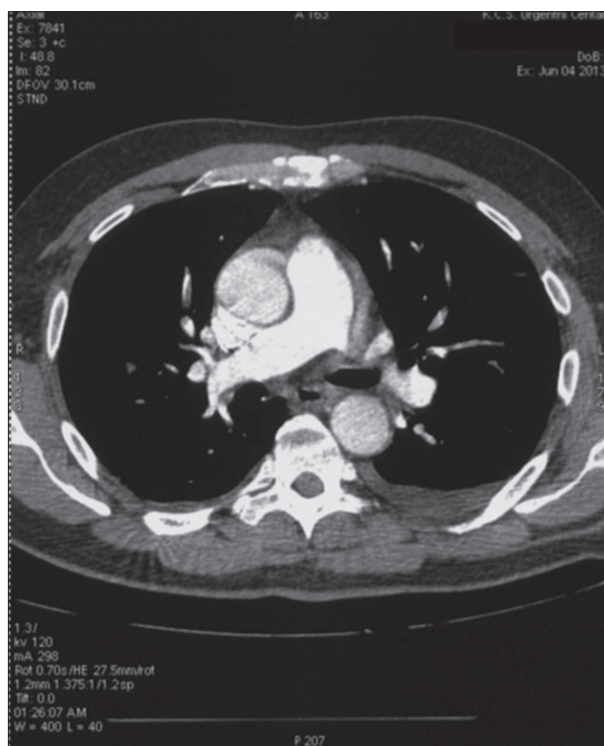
Computed tomography of the thorax – thrombosis in lobar branches of the right pulmonary artery
